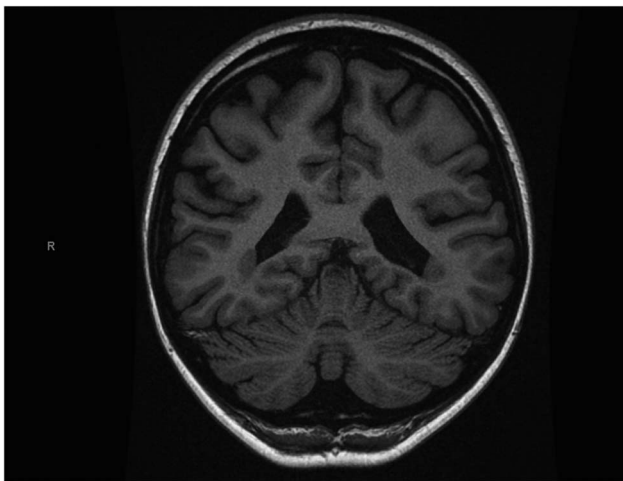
MRI T1-weighted sagittal brain. Bilateral subependymal heterotopic nodules.
